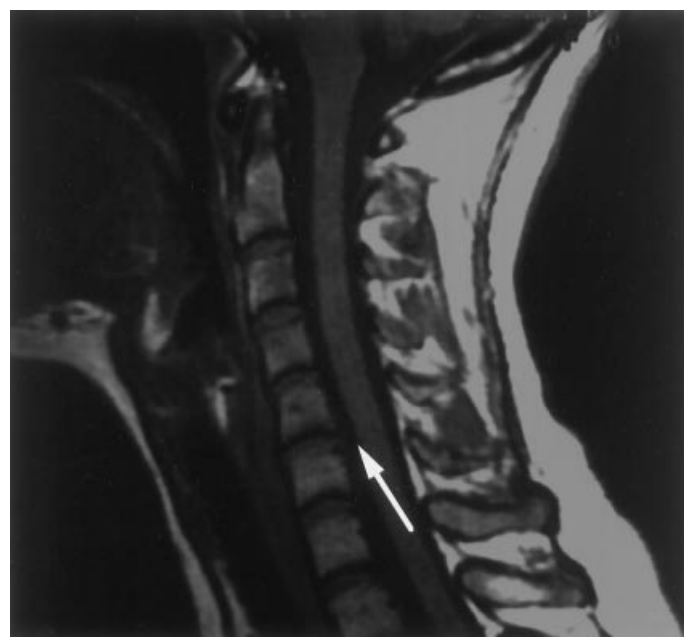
MRI of sagittal view through the cervical spine shows a disk defect which is impinging on the spinal cord. MRI of the spine is also the optimum diagnostic imaging method for low back pain.
